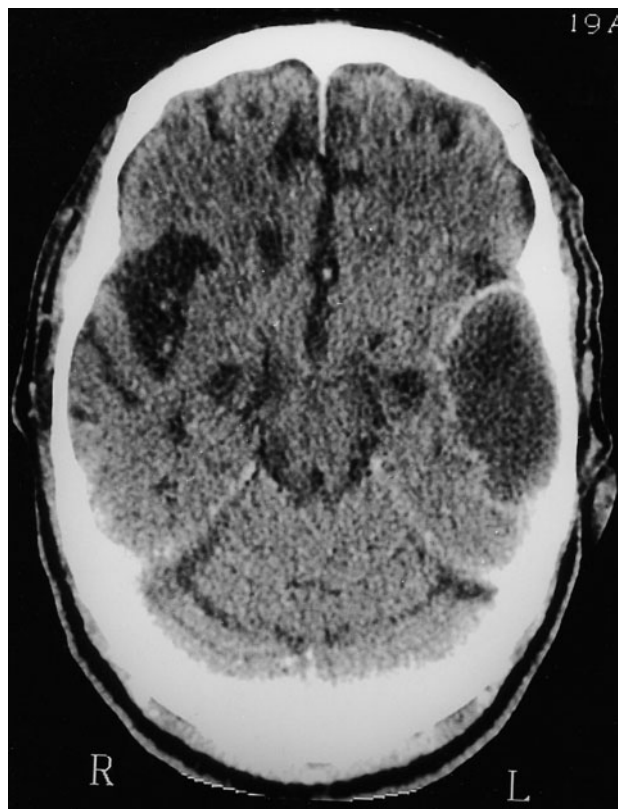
A similar CT scan cut done (with contrast) two weeks later, showing large ring enhancement in the previously hypodense area compatible with a brain abscess.
